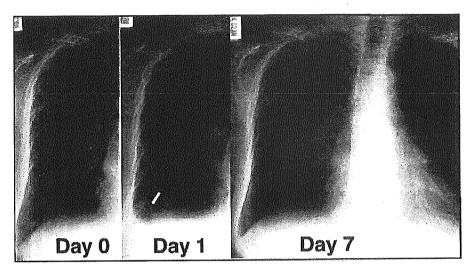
Chest roentgenogram showing pleural effusion (*arrow*) on the day after B-RTO. Effusion was not associated with clinical symptoms such as cough or chest pain.
